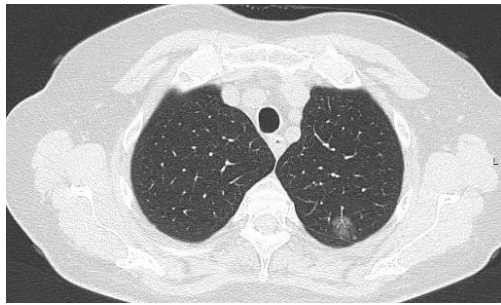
Computed Tomography image of pure ground-glass opacity (GGO).
